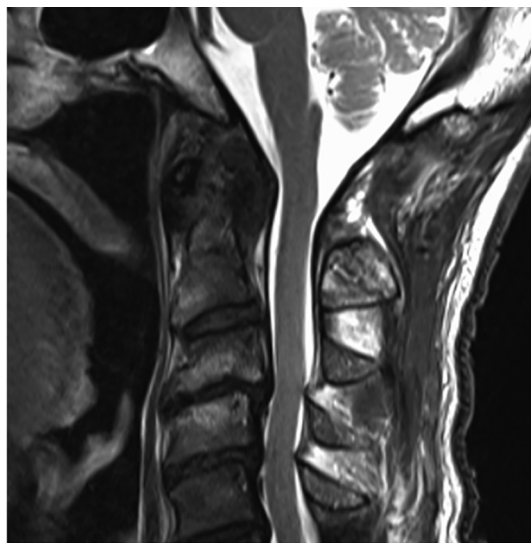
Patient follow-up magnetic resonance imaging (MRI) scan. A follow-up MRI scan was performed after 3 months and showed effective relief of spinal cord compression.
